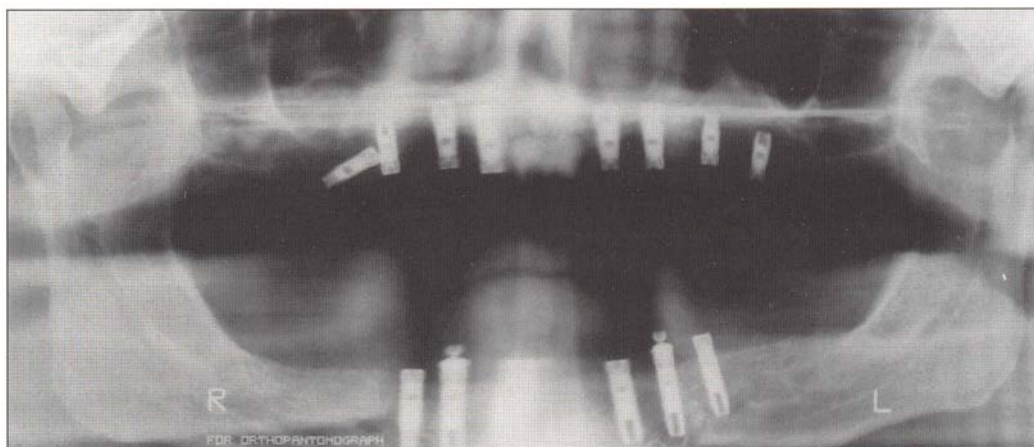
Postoperative panoramic radiograph of a patient who underwent bilateral sinus augmentation and secondary maxillary implant placement. Prior to second-stage implant surgery, the radiograph demonstrated the loss of the maxillary right posterior implant. Bone loss in the augmented area led to the implant failure.
